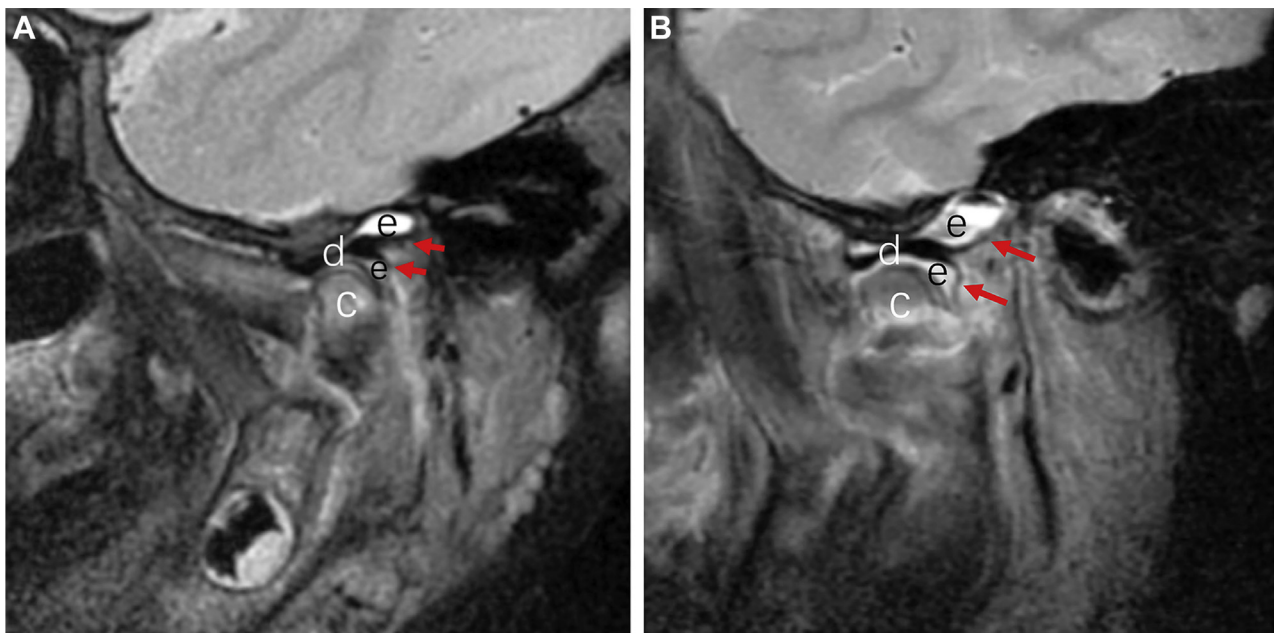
T2-weighted sagittal magnetic resonance images (MRIs) of nondislocated and dislocated fractures. *A*, MRI of a 2-year-old girl 5 days after her injury. The main part of the fractured condyle (*c*) was located within the fossa, the disc was partially displaced (*d*) and joint effusion was present in the superior and inferior cavities both (*e*). The retrodiscal attachments were intact (arrows). *B*, MRI of an 11-year-old girl 5 days after her injury. The fractured condyle (*c*) was dislocated from the fossa, the disc was totally displaced (*d*), and joint effusion (*e*) was present in the superior and inferior joint spaces, showing as a “double-tenpins sign.” The superior and inferior retrodiscal attachments were intact (arrows).
